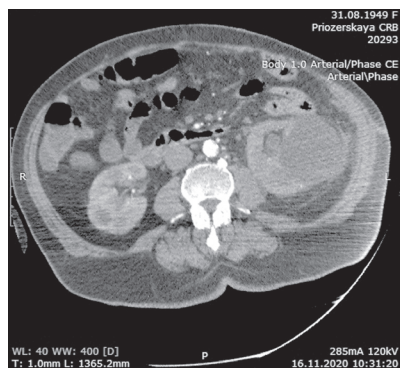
Multispiral computed tomogram of the kidneys and retroperitoneal space
